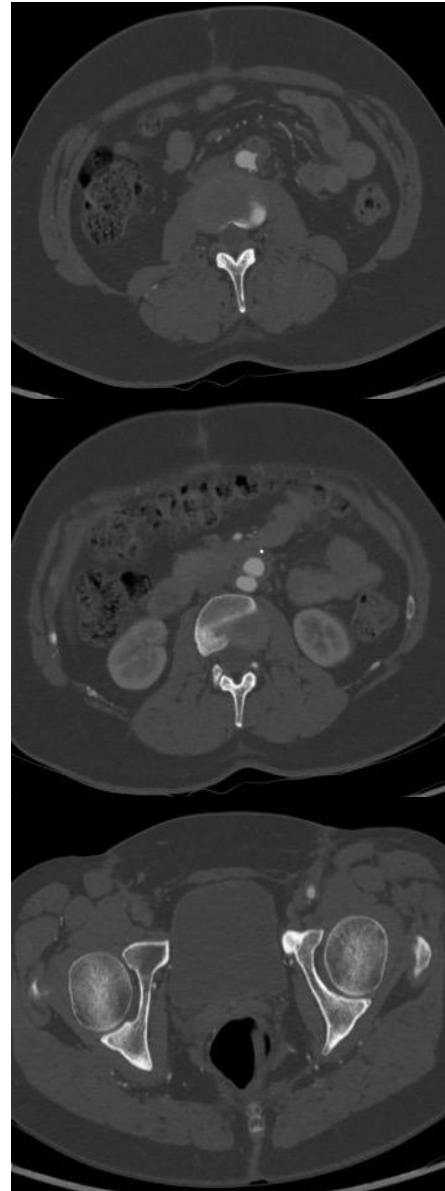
CTA 3 months post-AoFG showing occlusion of the right CIA, EIA and CFA; the AoFG is occluded 1.5 cm distal to the proximal anastomosis with retrograde filling of the left limb.
